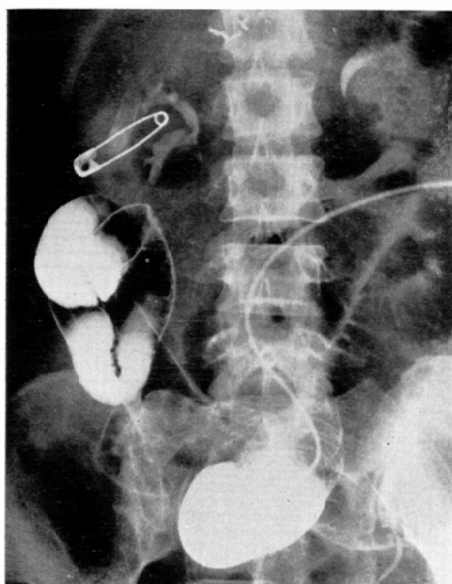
Case 4. Roentgenography with a barium meal applied through feeding fistula. The obstructed site is consistent with the area supplied by the extended intestinal branches.
